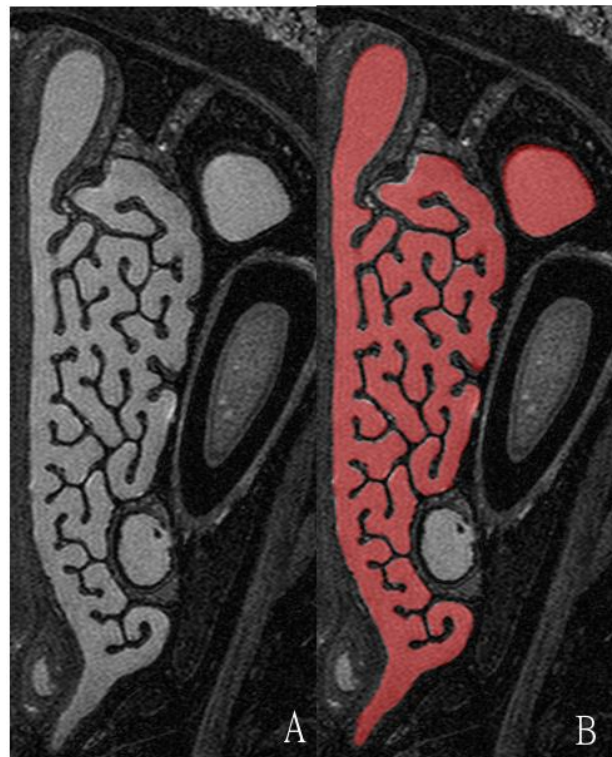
A, raw MRI data slice. B, segmented airway cross-section.
